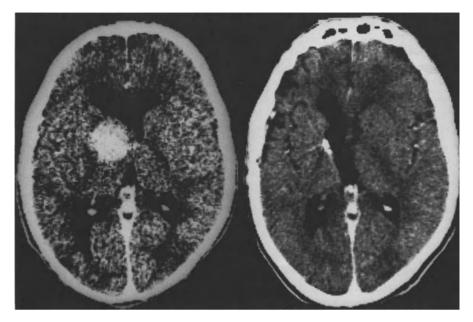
CT examination of a patient with a pilocytic astrocytoma, *left* preoperatively and *right* 7 years after interstitial irradiation
